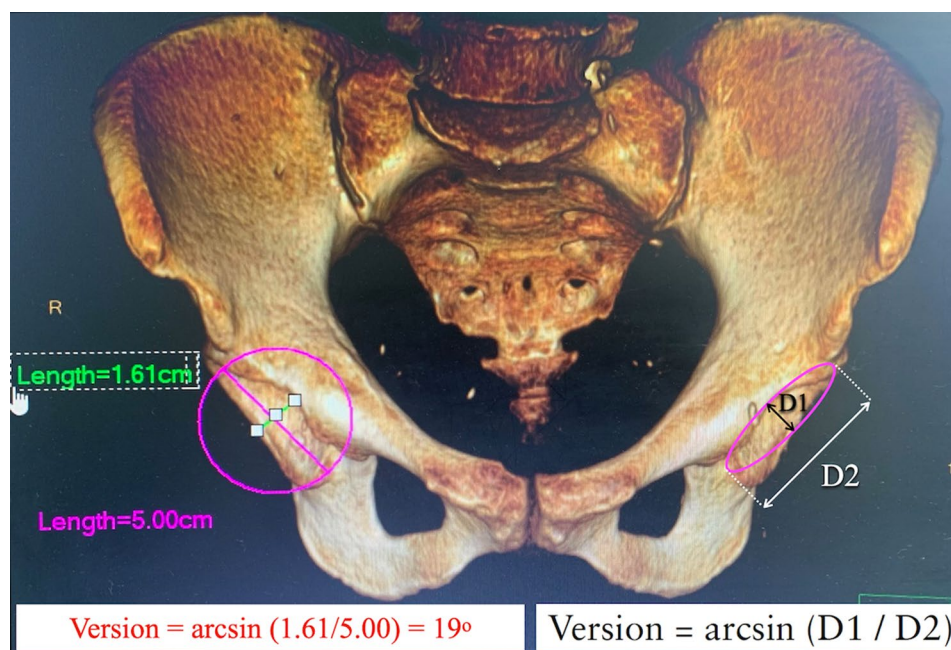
A circle was drawn around the acetabulum and resized to match the templated cup size. A diameter line, parallel to the acetabular rim's long axis, and a perpendicular short axis were drawn. Native radiographic anteversion was calculated using the formula: $\arcsin [\text{short axis} / \text{long axis}]$
